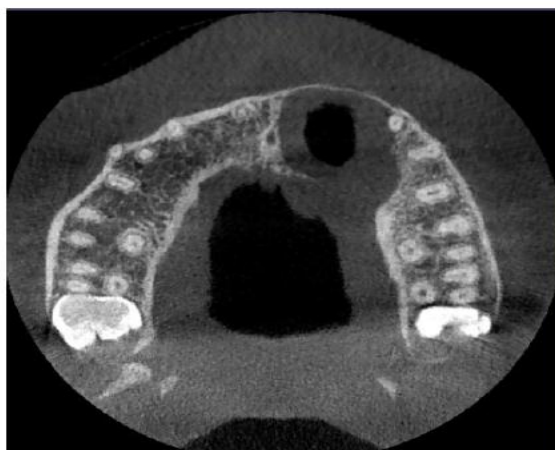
CBCT, Bone defect in Coronal view.
